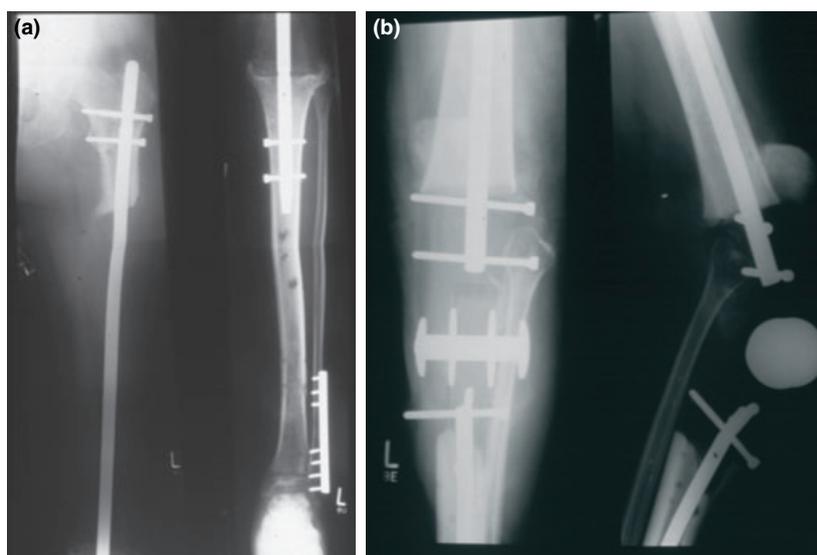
(a) Radiography of left femur with hip and knee joint: Osseous defect including femur, knee joint and prox. tibia (length 44 cm), temporarily stabilised with an intramedullary arthrodesis nail (b) Radiography of right knee joint: Osseous defect stabilized with a hinge arthroplasty.
